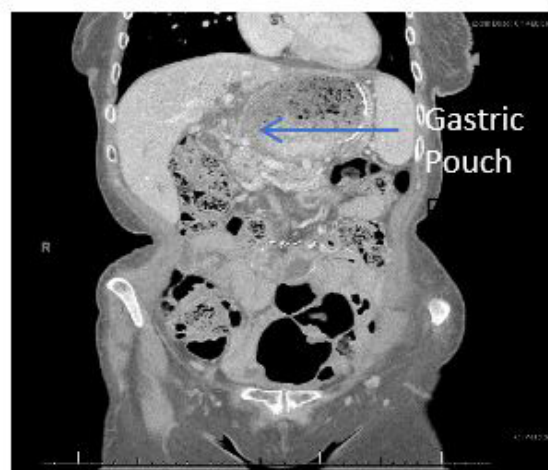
Abdominal CT with IV contrast showing gastric-pouch dilation (coronal plane).
